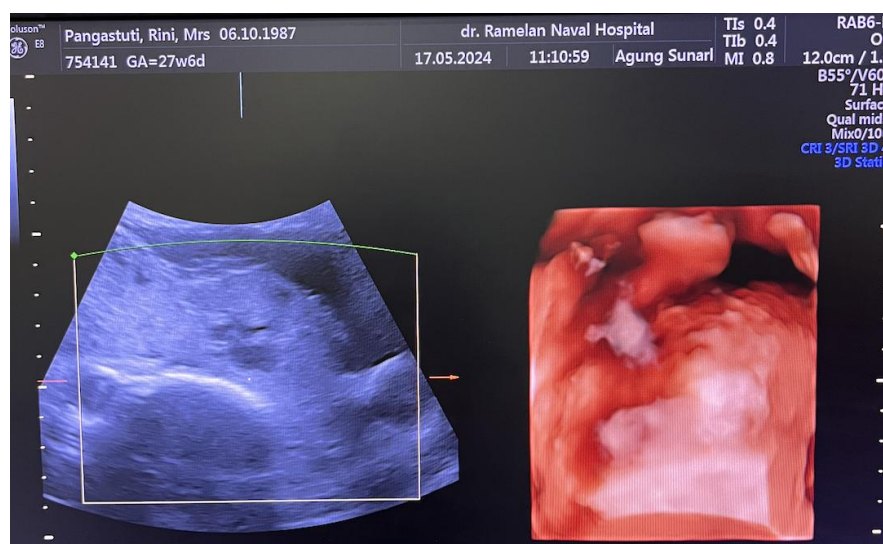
The ultrasound imaging
